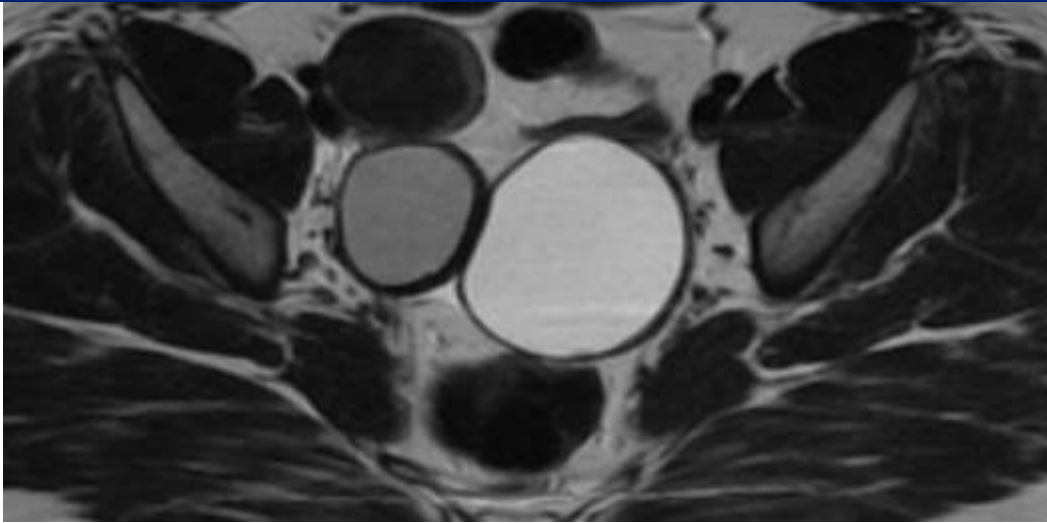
2 lateral uterine formations in asignal, producing a shading sing appearance evoking endometriomas (T2-weighted MRI)
